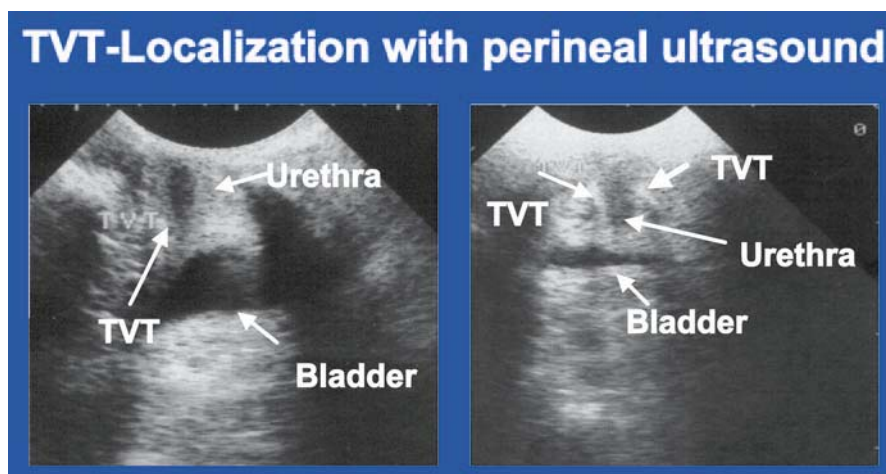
TVT localization with perineal ultrasound
